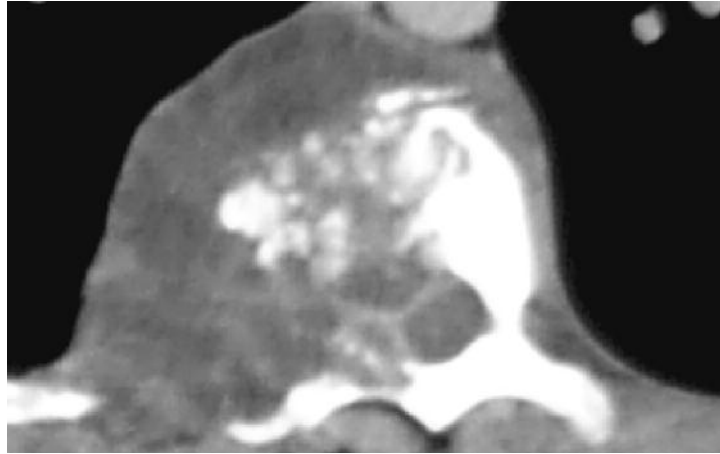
Axial image of preoperative CT scan suggesting a mass eroding the T10 vertebral bodies.
